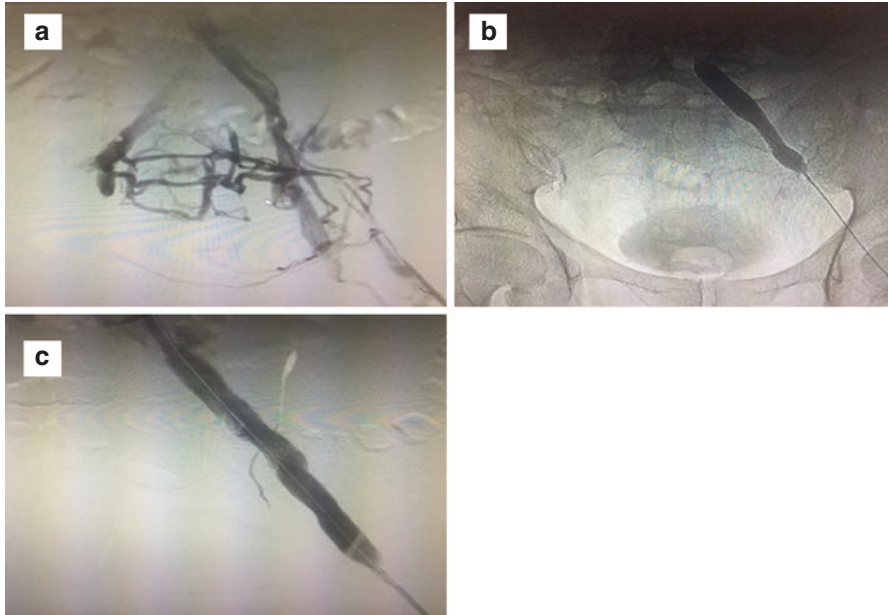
Iliac vein occlusion in venous ulcer patient. (a) Venogram found stenosis and marked collaterals seen; (b) balloon venoplasty; (c) venogram after venoplasty and stent placement found absence of collaterals. Technical consideration [7]: (i) Large bore stent is mandatory in all cases to prevent recoil from fibrosis (Inferior vena cava—20 mm, common iliac vein 16 mm, external iliac vein 14 mm, and common femoral vein 12 mm). (ii) Avoid skip area to prevent residual lesion and interstent stenosis. (iii) Proximal extension of stent usually be placed 2–3 cm above iliac vein bifurcation into inferior vena cava to prevent squeezing of the stent distally. (iv) Intravascular ultrasound is useful to located proper position of stent and lesion coverage
